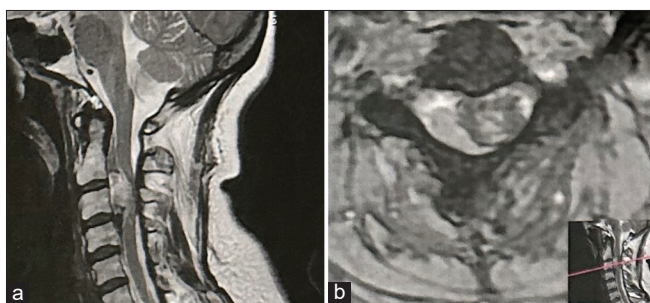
(a) Sagittal and (b) axial sections of a cervical spine magnetic resonance imaging on T2-weighted imaging (a and b) showing an anterior intradural extramedullary lesion at the level of C2–C4.
